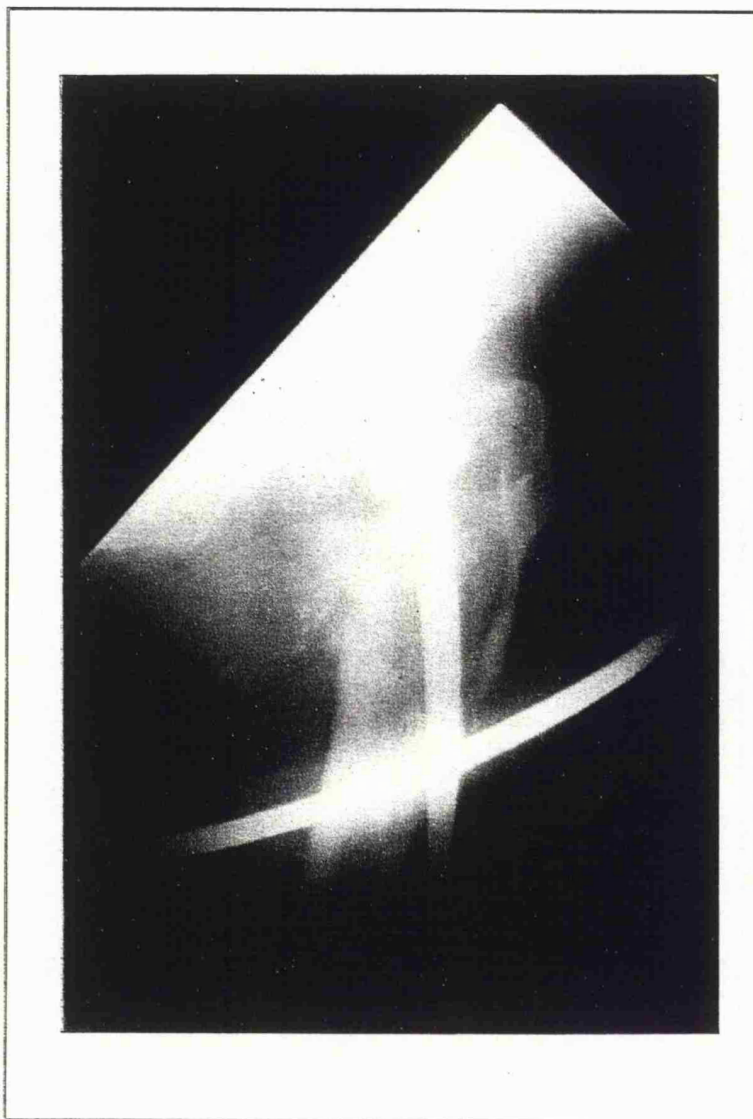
A lateral radiograph showing a femoral fracture around the stem of a Thompson prosthesis.
